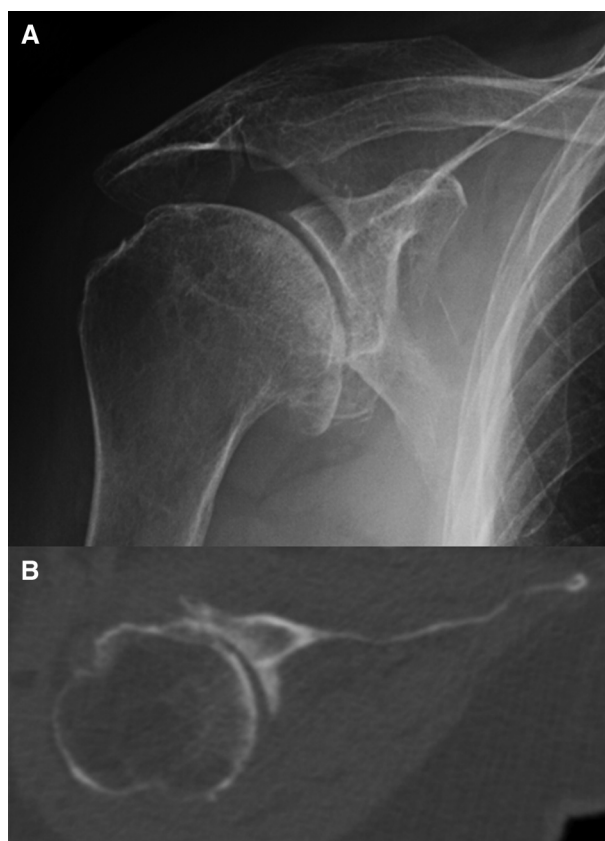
Plain film (A) and axial CT cut (B) showing severe glenohumeral arthritis with joint line medialization and eccentric posterior wear.
